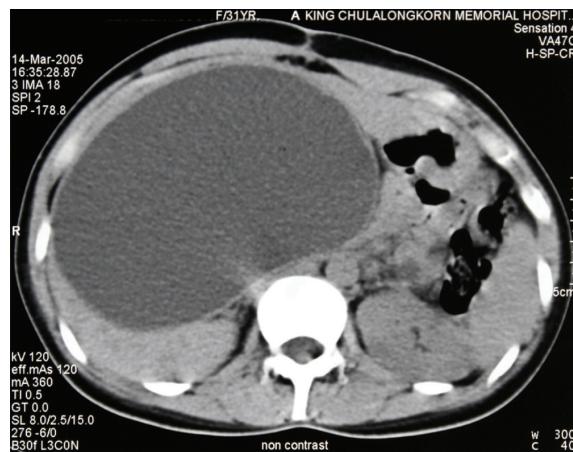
CT scan of the abdomen on 14th March 2005, 6 weeks after partial excision of the cyst wall at the first operation. Recurrent large cystic lesion of the liver (15 x 10 x 17 cm in size) was demonstrated
